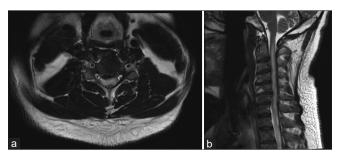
(a) Preoperative axial T2-weighted magnetic resonance imaging (MRI) of the cervical spine at C5. (b) Preoperative sagittal T2-weighted MRI of the cervical spine revealed spinal cord hyperintensity from the corticomedullary junction to the T1 level.
